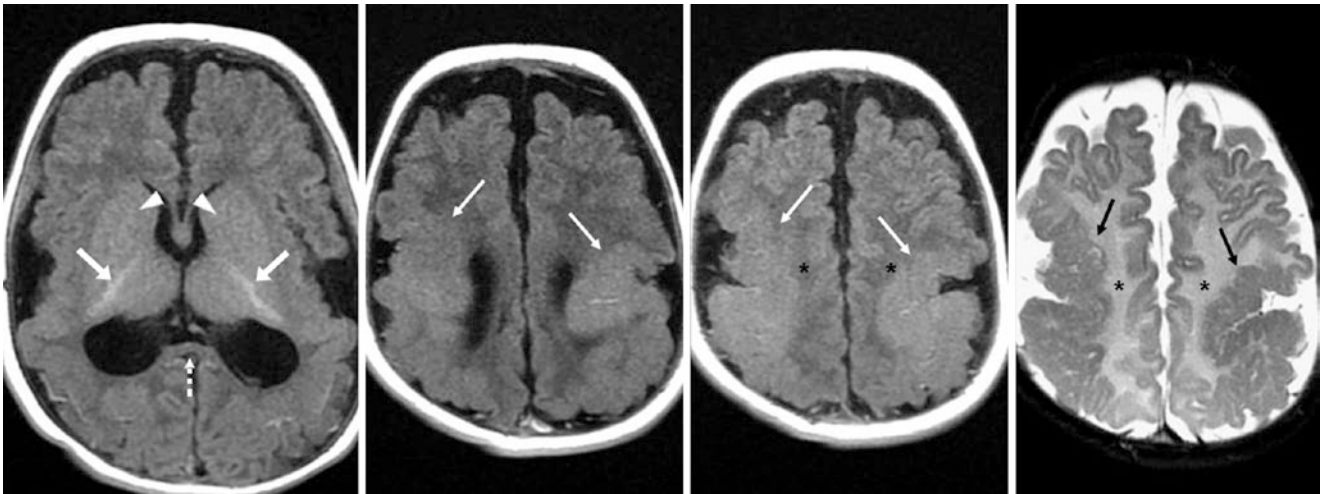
Comparison case of hypomyelination in congenital perisylvian polymicrogyria. A 5-month-old with motor delays had a 1.5T MRI with T1 FLAIR (*leftmost images*) and SE T2WI (*right*). The ALICs (*arrowheads*), CS (*dotted arrow*) and CG (*dashed arrow*) were
